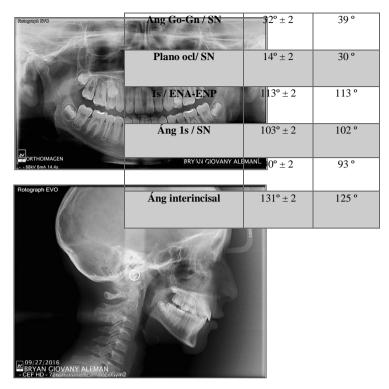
Panoramic x-ray, lateral x-ray and cephalometric summary
